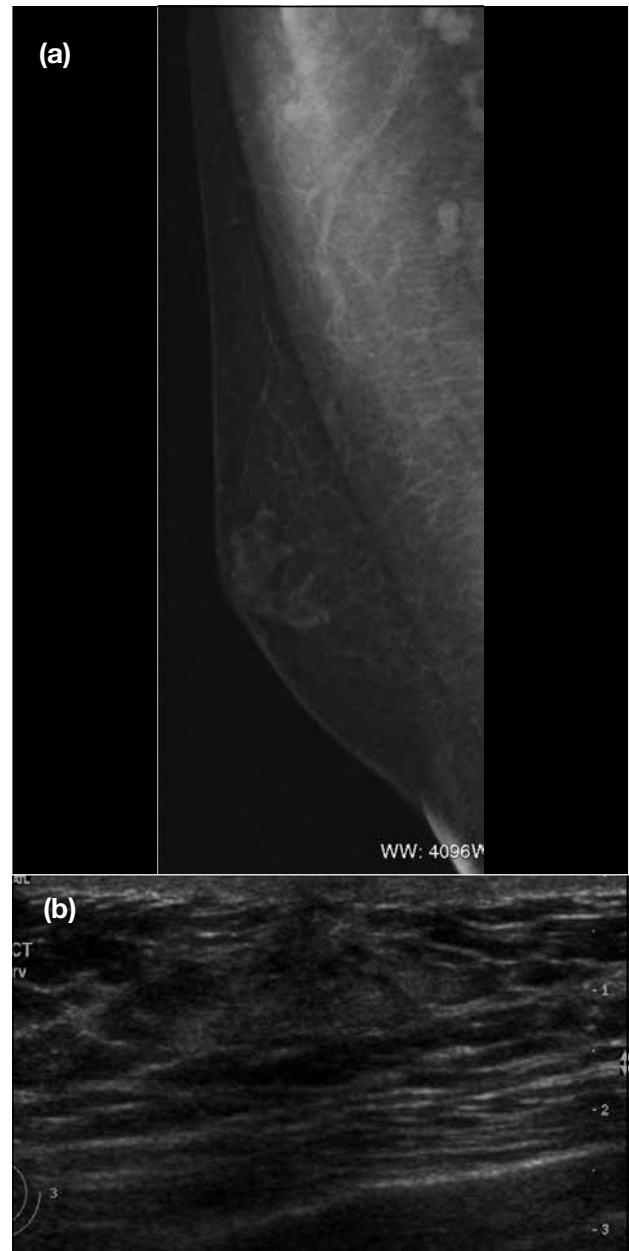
Chronic dendritic gynaecomastia: (a) Mediolateral oblique mammogram showing a dendritic retroareolar density with posterior linear projections radiating into the surrounding tissue, unlike malignancy, there is no associated nipple retraction or skin thickening. (b) Supplementary ultrasound shows a retroareolar hypoechoic lesion with an anechoic star-shaped posterior border or finger-like projections insinuating into the surrounding echogenic fibrous breast tissue.
